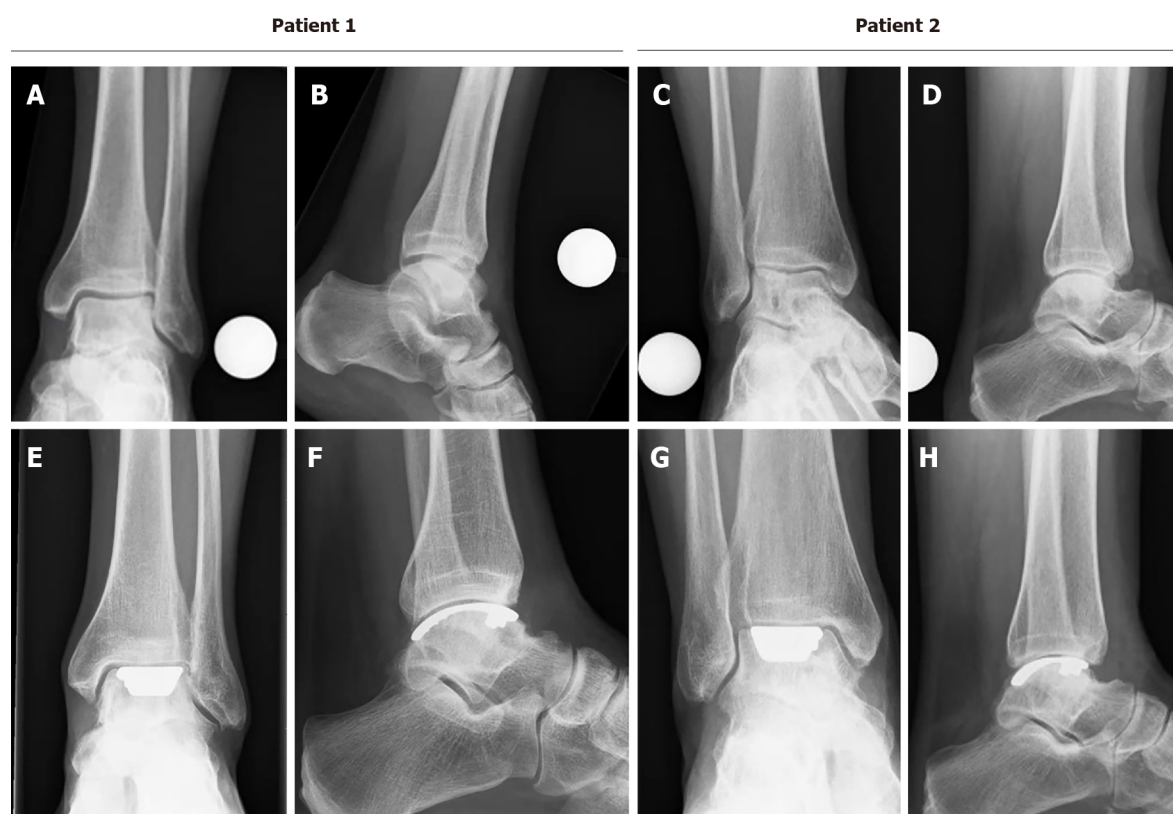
Preoperative and postoperative radiographs. A and C: Preoperative mortise radiographs; B and D: Preoperative lateral radiograph; E and G: Postoperative mortise radiograph (2-years); F and H: Postoperative radiograph.
